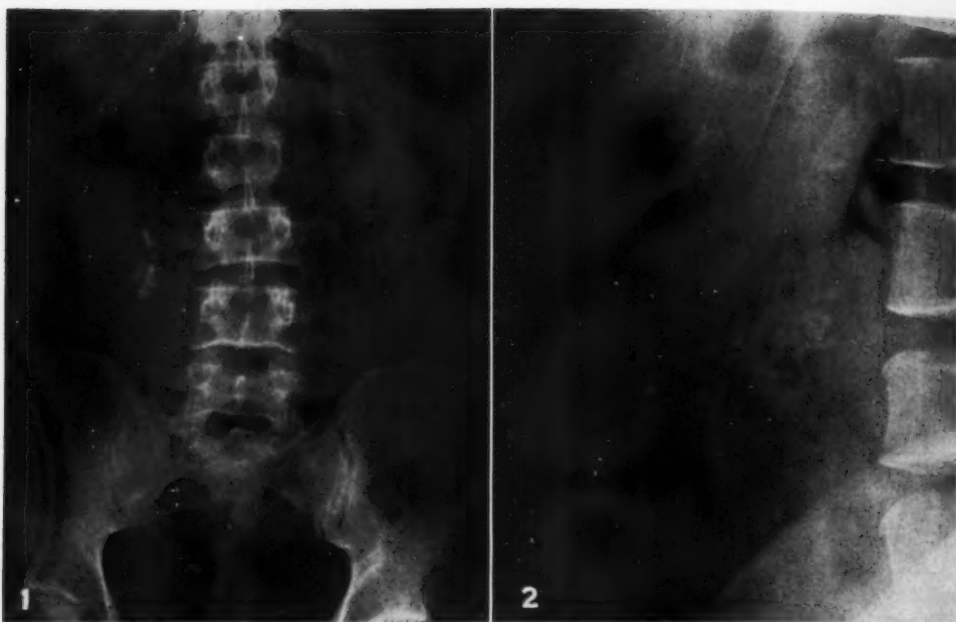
Anteroposterior roentgenogram of the abdomen revealing large soft-tissue mass, with central annular pattern of calcific deposits, in the right lower quadrant.
